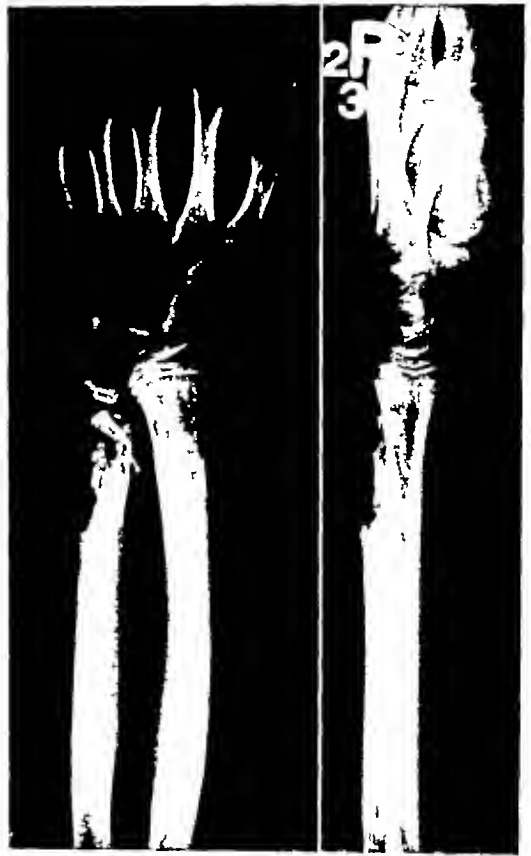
Roentgenogram taken Jan 13, 1936. There is a fracture of the lower end of the right ulna, with floating epiphysis, also there is considerable bone atrophy of the carpus.
